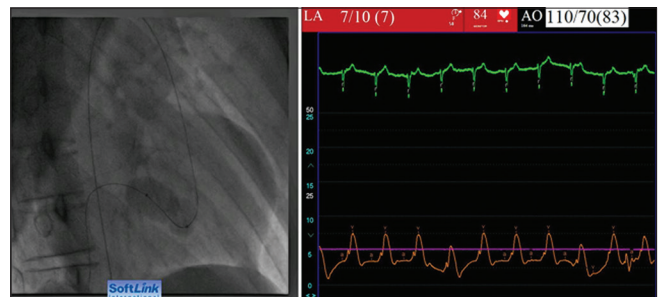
Systemic atrioventricular valve dilatation with peripheral balloon: A 22 × 40 mm Tyshak® balloon is introduced from the femoral artery across the stenotic valve and inflated under echocardiographic and fluoroscopic guidance. The mean left atrial pressure is decreased to 7 mmHg
